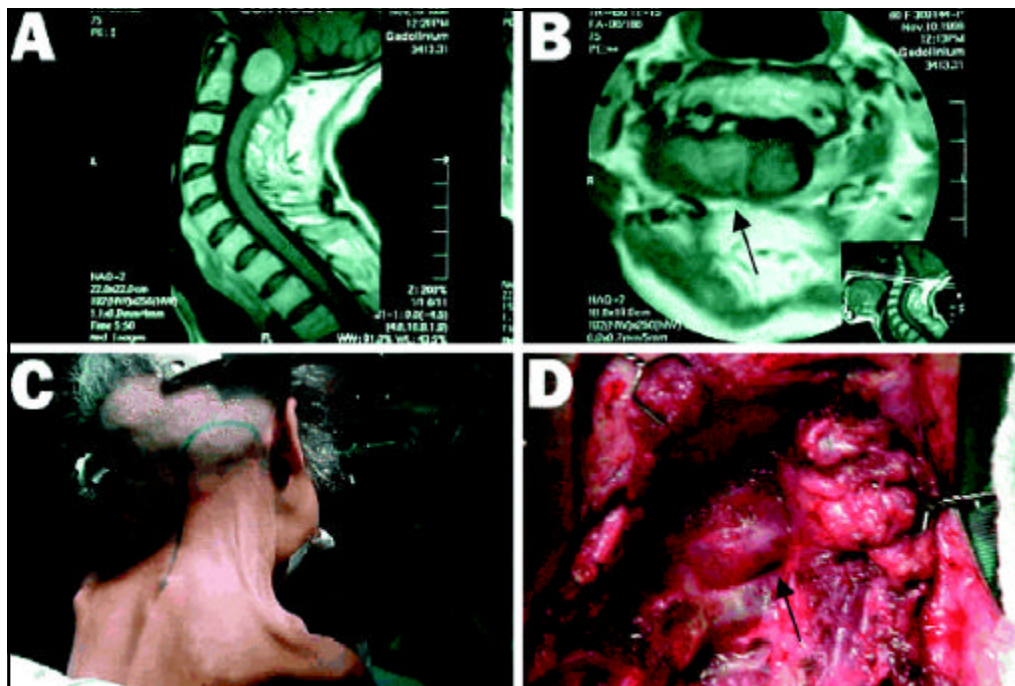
T1-weighted gadolinium-enhanced MRI (A- sagittal view, and B- axial view) reveals a mass lesion extending from the craniocervical junction to the vertebral artery. (C) The exposure was done using a hockey stick incision in the right side with the patient in the sitting position. (D) The lesion was seen after the removal of the ipsilateral posterior arc of the C1 vertebrae.
